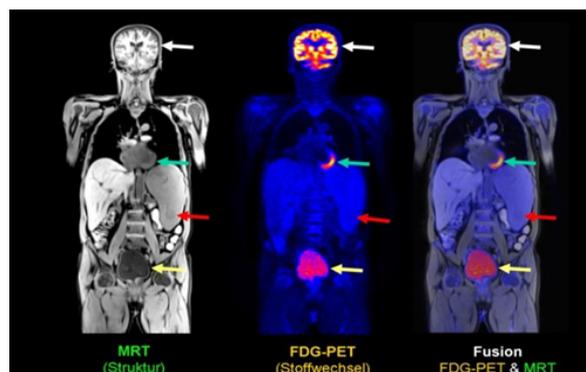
This MRI scan shows how cancer would grow in the future. Adapted from rediff news October 2014 08:44 IST [49].
